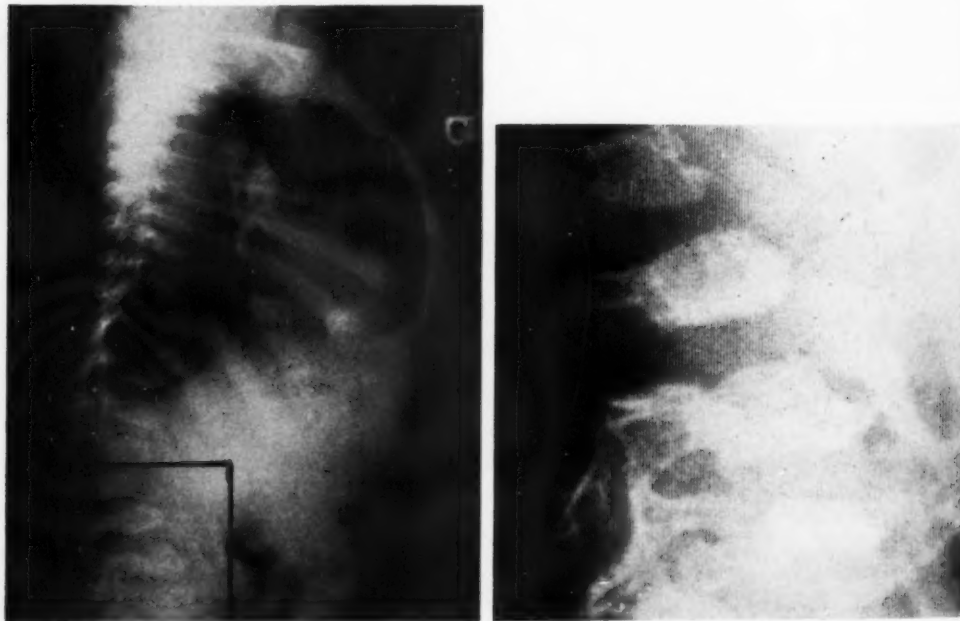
Lateral view of the lumbar spine of a boy of three years and five months who was referred to the hospital for study because of deformity of the spine and chest. Films of all the bones showed the typical manifestations of osteochondrodystrophy of the Morquio type. Note the similarity of the radiographic appearance of the abnormally shaped vertebral bodies to those shown in Figs. 3 and 4.
